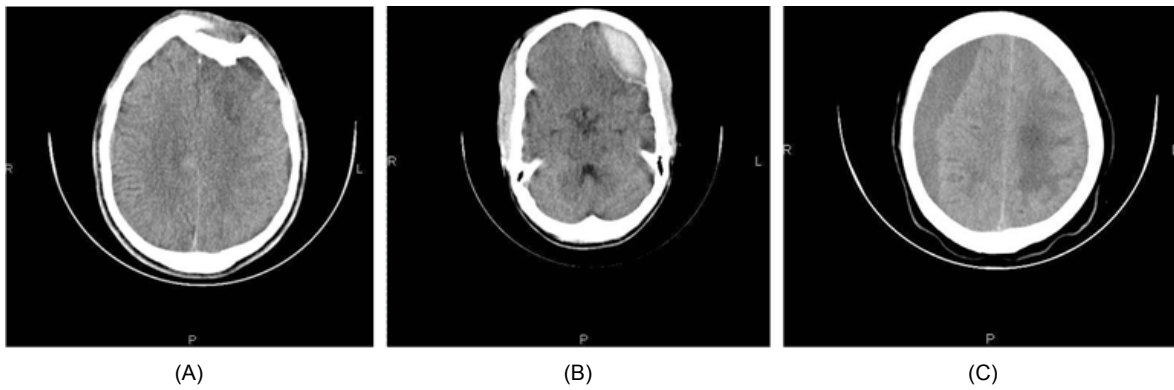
CT scans of (A) depressed skull fracture; (B) epidural haematoma; (C) chronic subdural haematoma.
